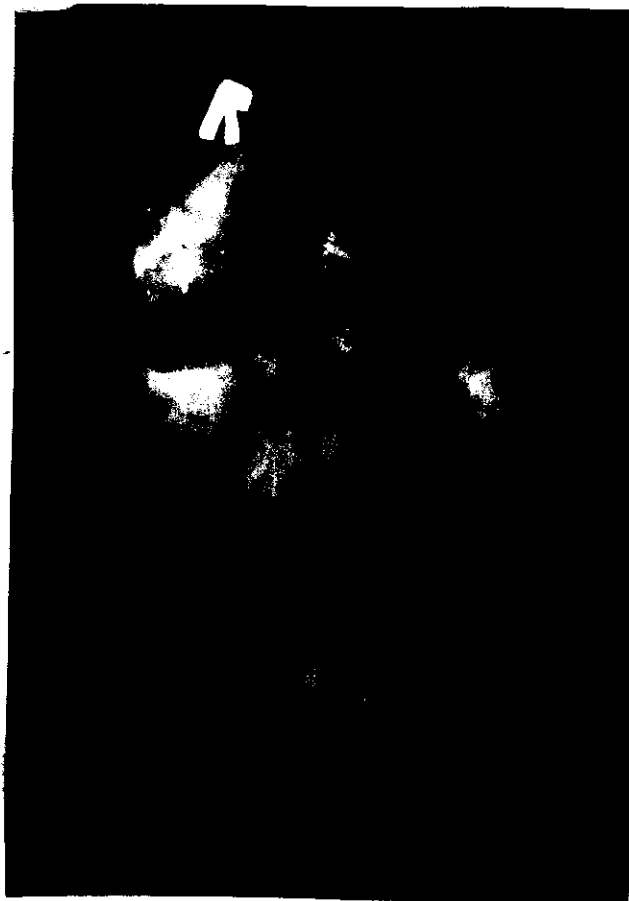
X-ray of maxillary sinuses, occipitomenal view with open mouth, showing small sized cavity of both maxillary sinuses with complete opacity of right side and partial opacity of left side.
